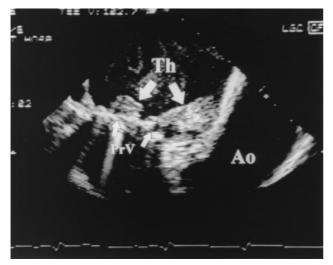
Transesophageal echocardiogram showing a thrombus (large arrows) visualized as a soft mass on the atrial side of a bileaflet mitral prosthetic valve. There is extension of the thrombus to the left atrial wall. Small arrows indicate the level of the prosthesis. Ao = aorta; PrV = prosthetic valve; Th = thrombus.
